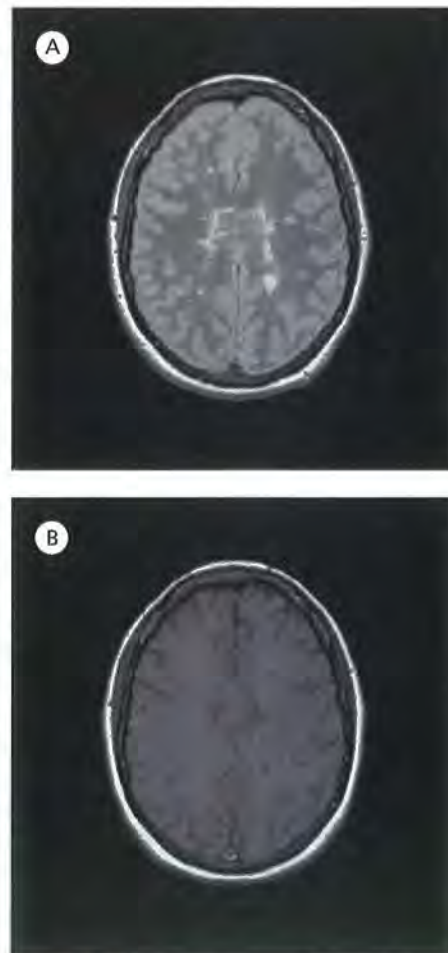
(A) T_2 -weighted and (B) T_1 -weighted MRI in multiple sclerosis. A minority of the T_2 lesions are visible as areas of T_1 hypointensity (colloquially called 'black holes').
